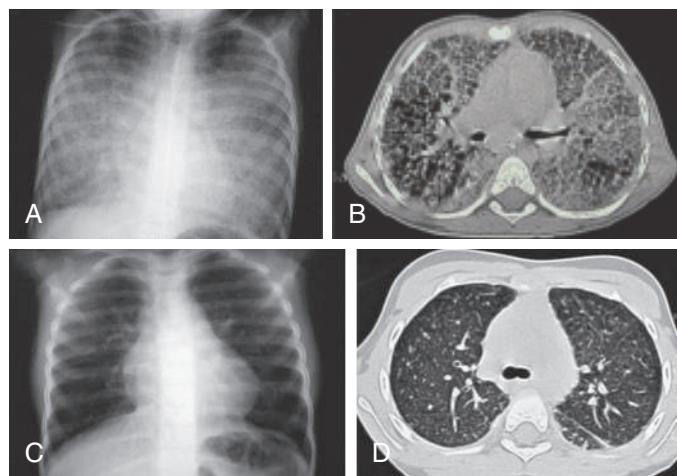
A and B, Severe pulmonary alveolar proteinosis in a 5-year-old child before therapeutic lung lavage. A, Chest radiograph shows diffuse alveolar and interstitial infiltrates. B, CT scan demonstrates major air space opacities and crazy-paving pattern. C and D, Same patient after 12 therapeutic lung lavages. C, Chest radiograph demonstrates improvement of alveolointerstitial infiltrates. D, CT scan shows regression of the air space opacities with a residual micronodular pattern. (From De Blic J. Pulmonary alveolar proteinosis in children. *Paediatr Respir Rev*. 2004;5:316–322.)
